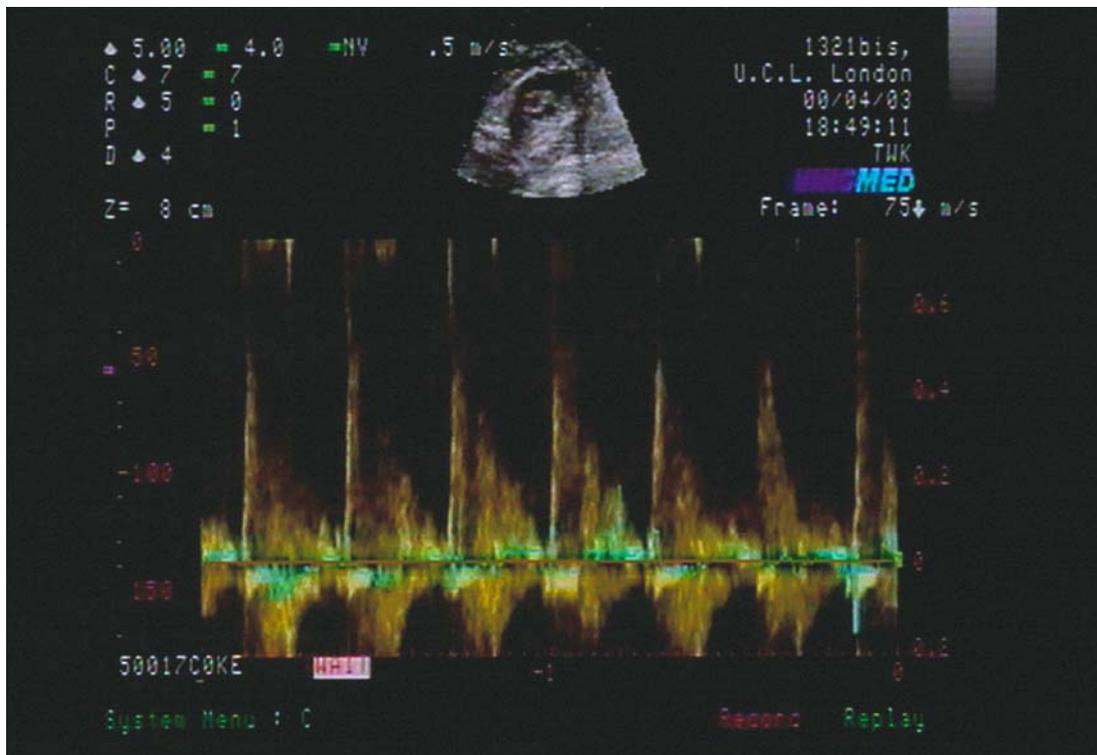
Colour-Doppler US from the umbilical artery to prove fetal viability
